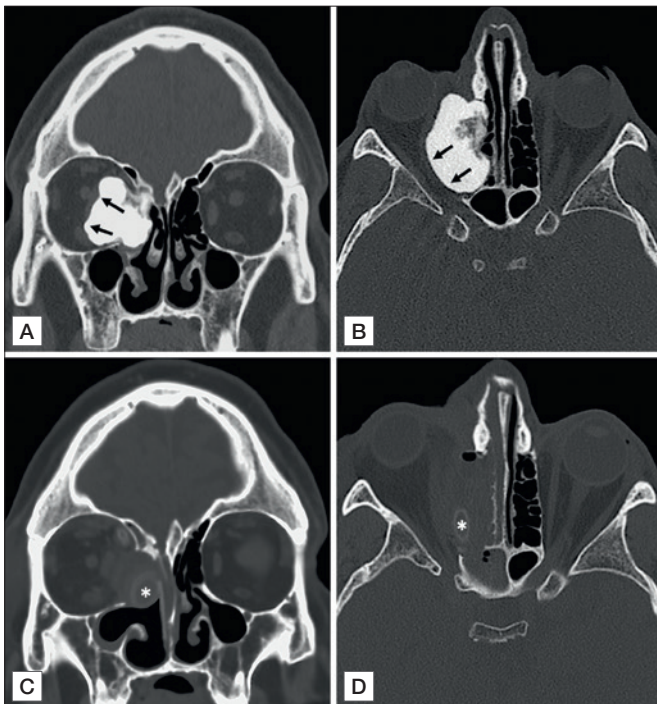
Coronal (A) and axial (B) CT scan of a 32 year-old male affected by ivory osteoma with right intraorbital extension. White arrows in A and B highlight the displacement of the extrinsic ocular muscles. The patient was submitted to endoscopic endonasal resection of the lesion using the cavitation technique. The early post-operative CT scan performed 24 hours after surgery (panels C and D) ruled out any intraorbital complication. White asterisks in C and D indicate silicon roll sheets placed to maintain the orbital content within the orbital cavity and therefore prevent postoperative sequelae.
